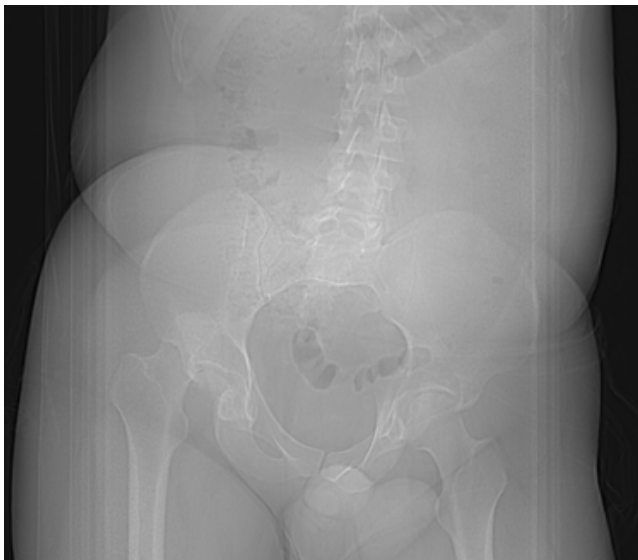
Anteroposterior x-ray of the pelvis with visible dislocation of the hip joint and fracture of the femoral head.
